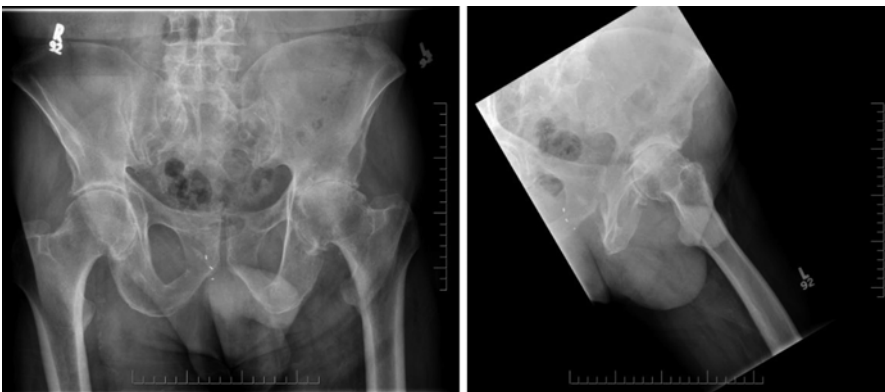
AP pelvis and lateral radiograph of left hip showing typical findings of osteoarthritis including joint space narrowing, sclerosis, and osteophyte formation
